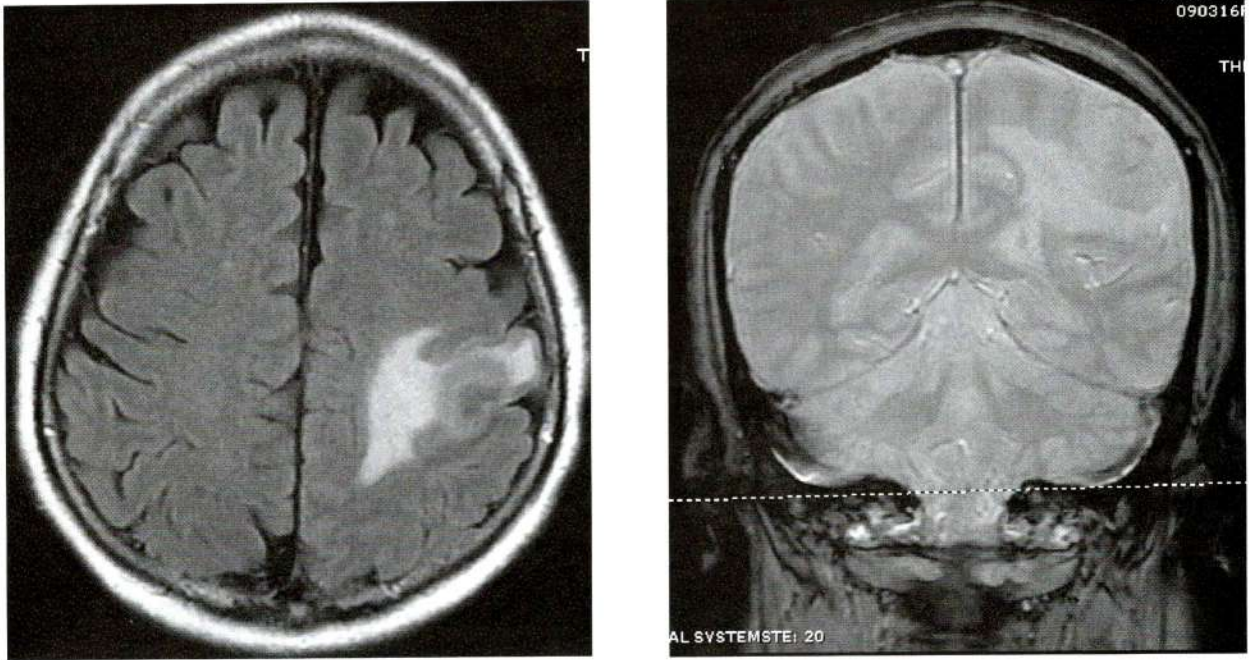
Axial FLAIR and coronal GRE-T2W better demonstrated dark T2W signal wall lesion with mild-hyperintense-T2W signal change in central portion.
